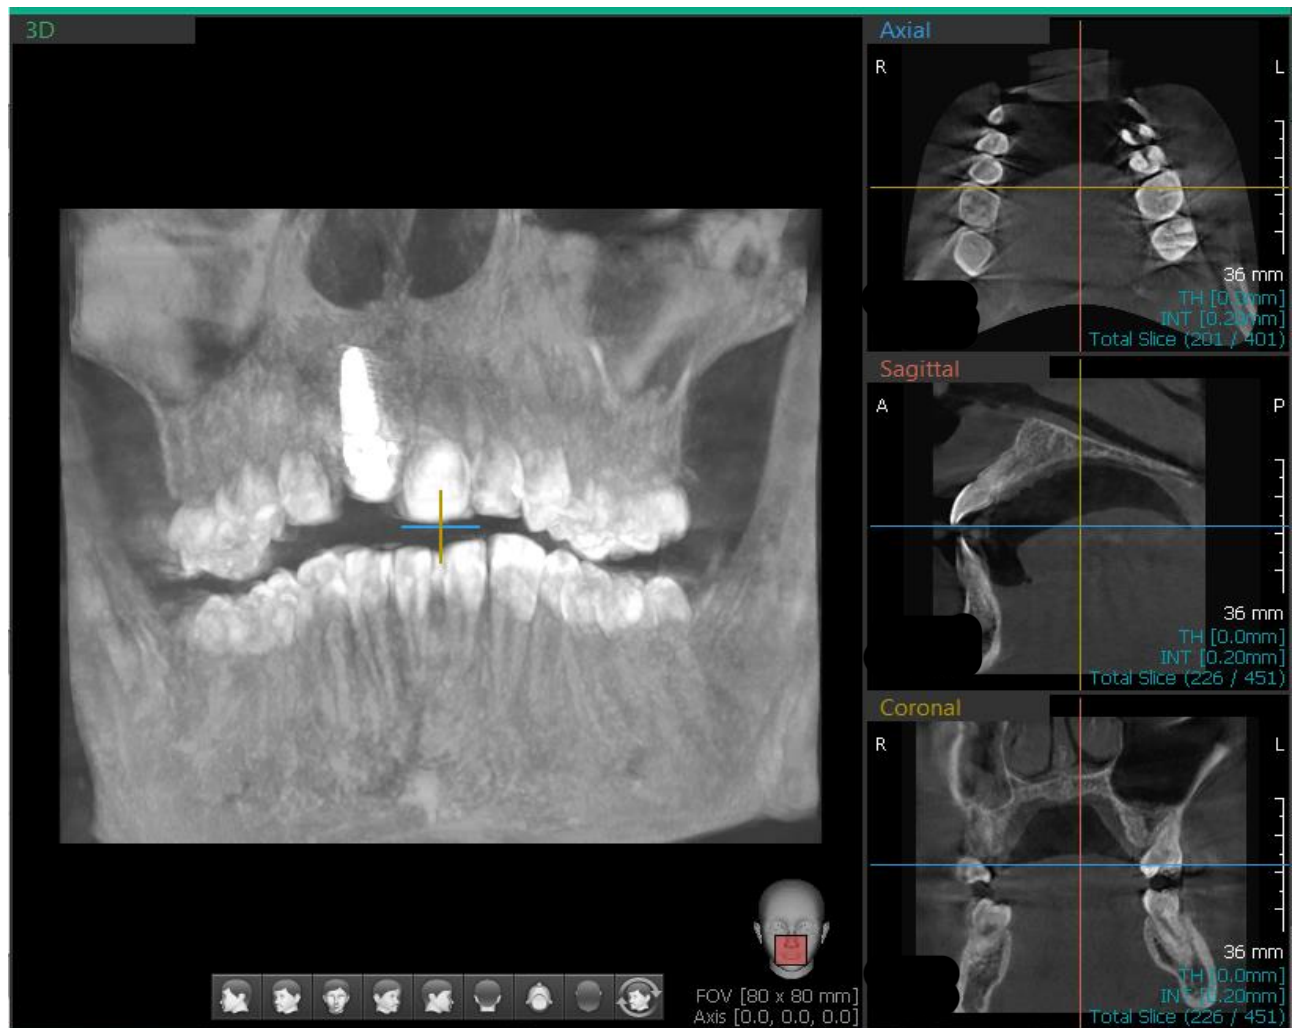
Post-operative CBCT showing implant position in axial, sagittal, and coronal planes, confirming correct angulation and complete bony support in the anterior maxilla
